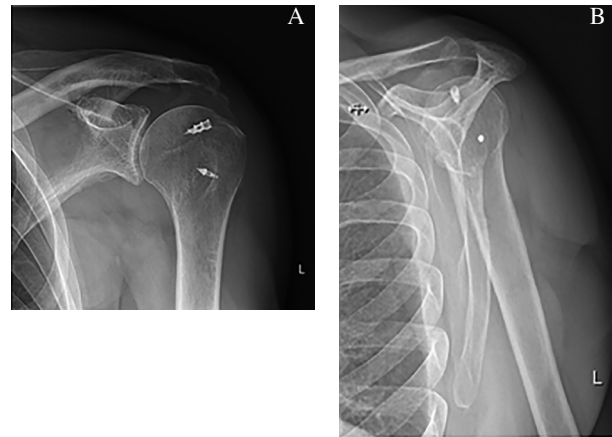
Postoperative plain radiographs, 3 months after surgery: true AP view/Grashey view (A), and lateral Y view (B), show an important calcification or ossification of the shoulder in the subacromial space.
